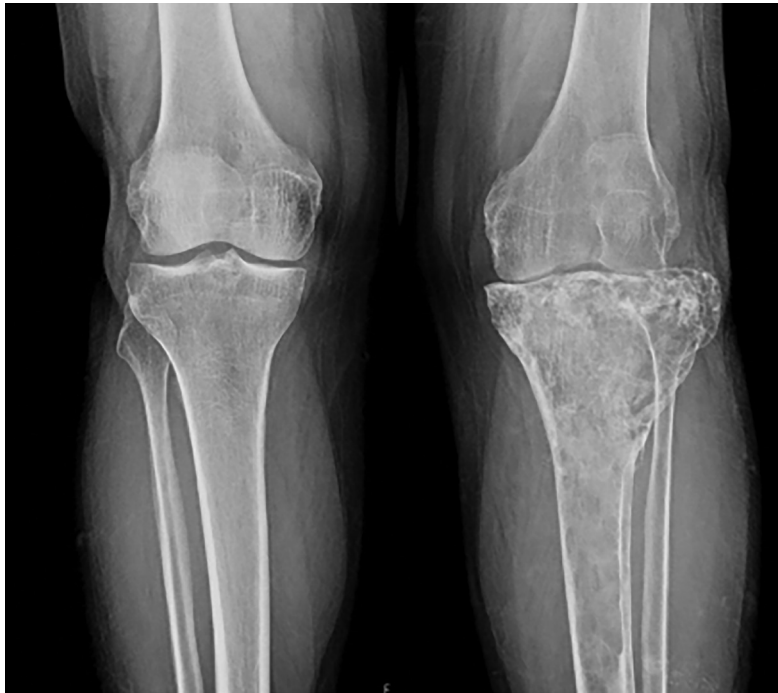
A 54-year-old male patient presented with progressively worsening pain and swelling localized to the left knee. Initial radiological evaluation using anteroposterior X-ray imaging demonstrated extensive lytic-destructive lesions predominantly involving the proximal metaphysis of the left tibia. Radiographic features included marked trabecular disruption, cortical thinning, and expansion of the medullary cavity. Given these aggressive radiological findings, a primary bone malignancy, particularly chondrosarcoma, was considered a preliminary diagnosis.
